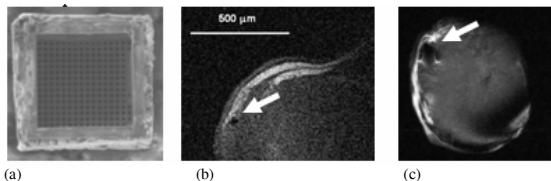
(a) SEM image of cell encapsulation microcontainer (2). MRI of a copper microcontainer with Faraday shielding of the device interior (b) and MRI of a nickel microcontainer with an enhanced region of negative contrast (c) provide the ability to uniquely distinguish and track the microcontainers post implantation.
